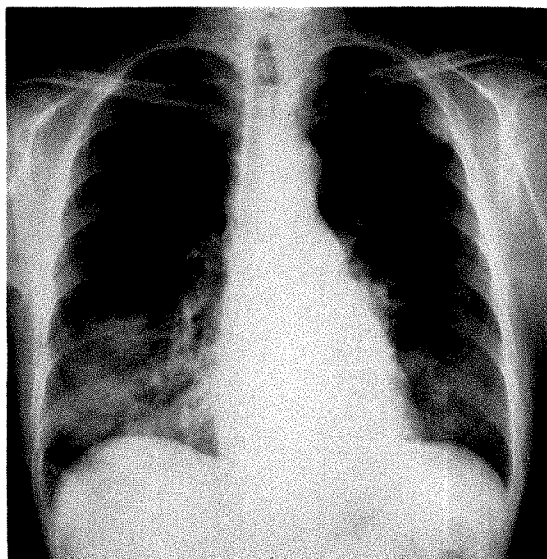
Chest roentgenogram, at the time of final hospital admission, shows multiple nodular densities in both lungs with cavitation near the right hilus. In addition, there is some consolidation in the right middle lobe. Note the narrow airway in the larynx.
